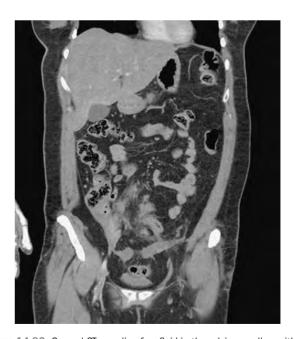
Coronal CT revealing free fluid in the pelvis as well as within the mesentery of the small bowel with inflammatory changes of the small bowel mesentery near the right lower quadrant;, these findings are concerning but not diagnostic for hollow viscous injury. At laparotomy the patient was found to have a full thickness mesenteric laceration with active bleeding and an associated antimesenteric small bowel injury.
